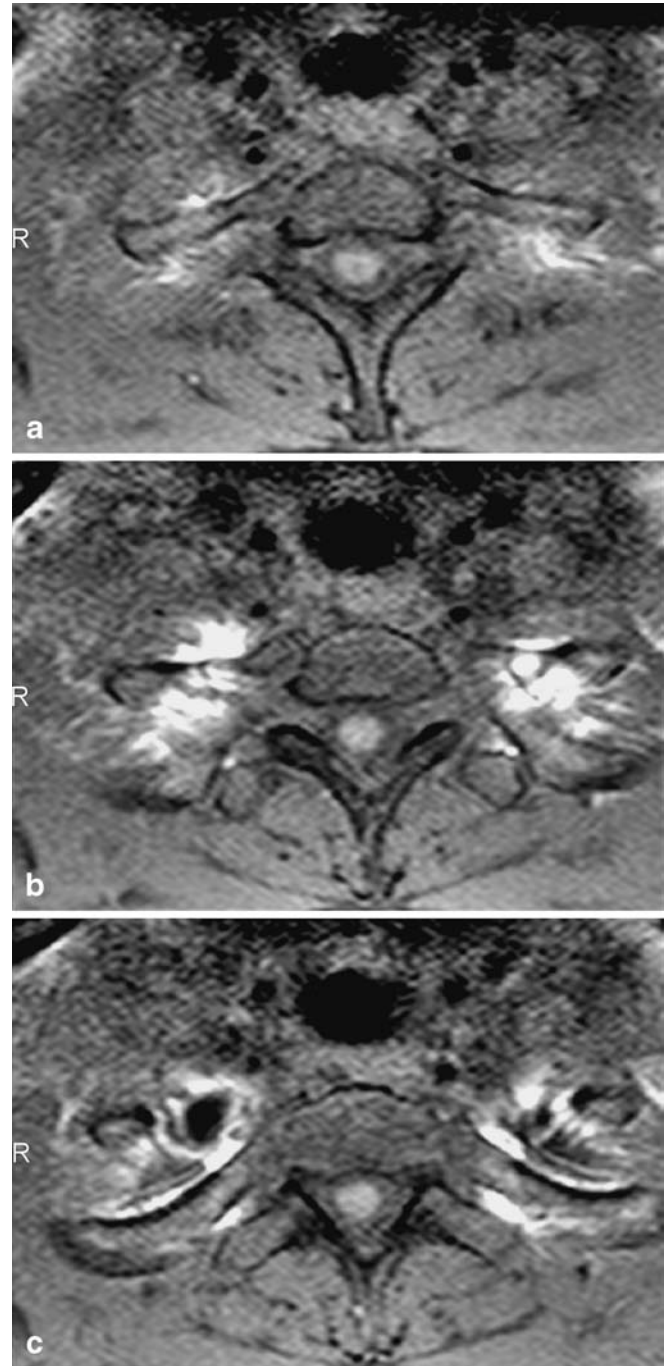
Axial T1-weighted images with SPIR in a control subject without intrathecal administration of Gd-DTPA. Imaging at level C7/TH1 (a) and TH1/TH2 (b) showing hyperintense signal in the paraspinal region around the ribs (a, b) and at the apices of the lung (c). There is no hyperintense signal along the nerve roots
